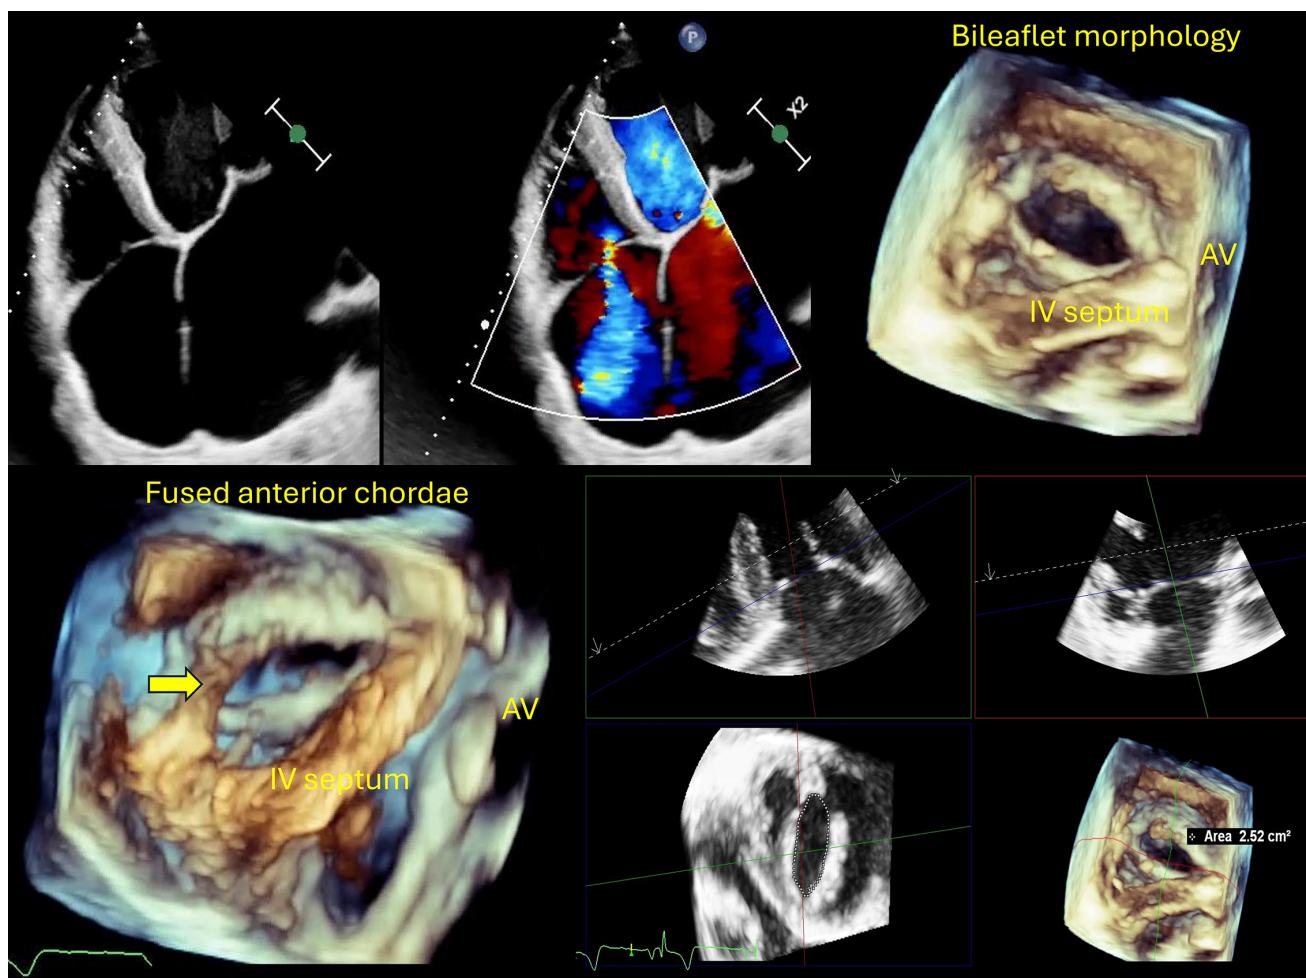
2D transthoracic echocardiography (TTE) showed mildly thickened leaflets and moderate central tricuspid regurgitation while 3D TTE demonstrated morphologically bi-leaflet valve (type II, septal, and non-septal configuration) with a fused anteroposterior commissure [7]. Multiplanar reconstruction, aligning the slicing planes at the valve ostium in maximum diastole, revealed an area of 2.52 cm² by direct planimetry. Additionally, thickened and fused chordae were clearly visualized suggestive of rheumatic tricuspid regurgitation without significant stenosis. The yellow arrow indicates the fused anterior chordae. 2D, two-dimensional; 3D, three-dimensional.
